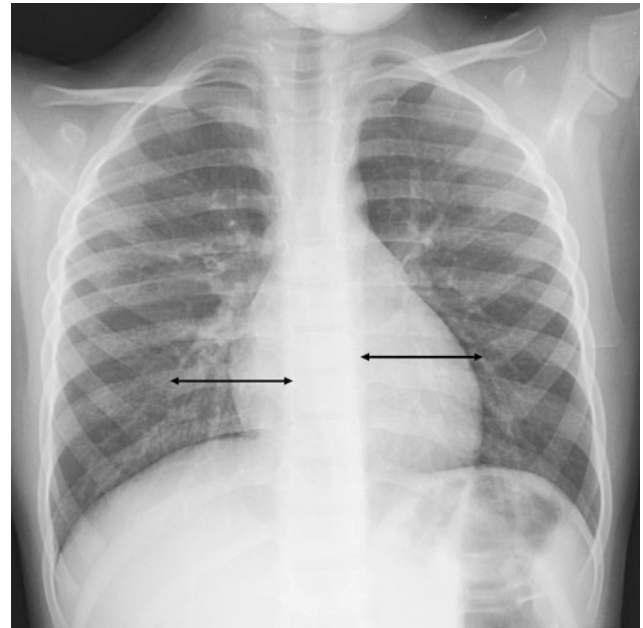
In a non-rotated frontal chest radiograph the distance between the medial aspect of the anterior costal arches and the spine is symmetric (arrows)
